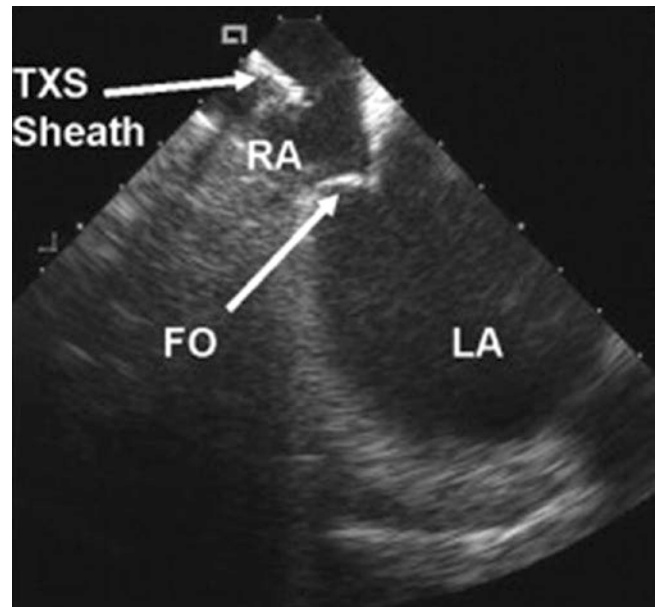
Intracardiac ultrasound to guide transseptal puncture during ablation for atrial fibrillation. Indentation of the foramen ovale (FO) by the transseptal sheath (TXS) before transseptal puncture (*Reproduced, with permission from: Callans DJ, Wood MA. How to use intracardiac echocardiography for atrial fibrillation procedures. Heart Rhythm. 2007;4(2):242–5*)
